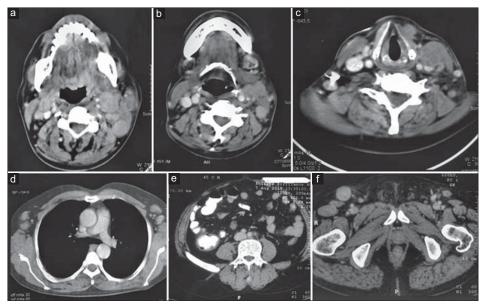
Contrast-enhanced computed tomography scan of the face, neck, thorax, and abdomen showing (a) diffuse homogenously enhancing sheet-like growth in base of the tongue, (b and c) multiple enlarged lymph nodes in bilateral cervical, (d) bilateral axillary, mediastinal, (e) retroperitoneal, and (f) bilateral superficial inguinal region
